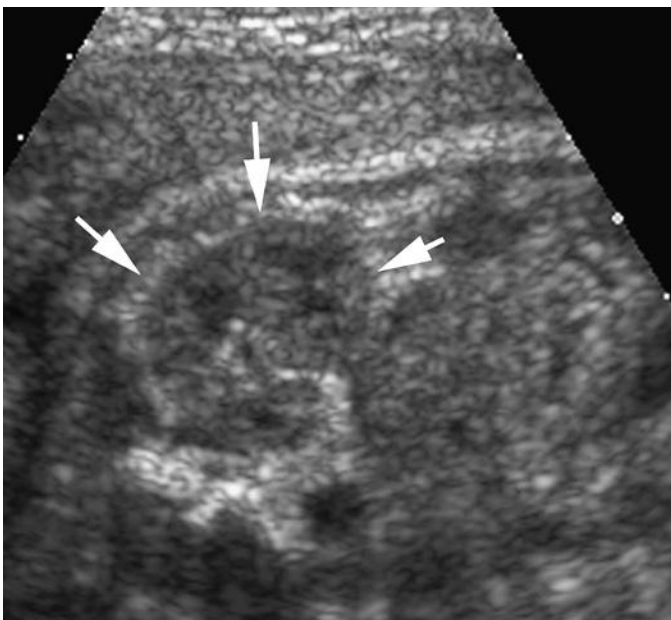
Transverse axial sonogram of a fetal kidney margined by perirenal fat (*arrows*). The brightly echogenic perirenal fat helps to sonographically outline the less echogenic renal parenchyma.
